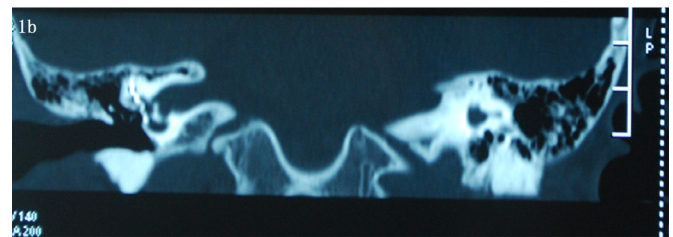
(A) X-ray in Stenver's view, showing the misplaced electrode entering probably the superior semicircular canal. (B) CT showing the misplaced electrode entering the superior semicircular canal.
